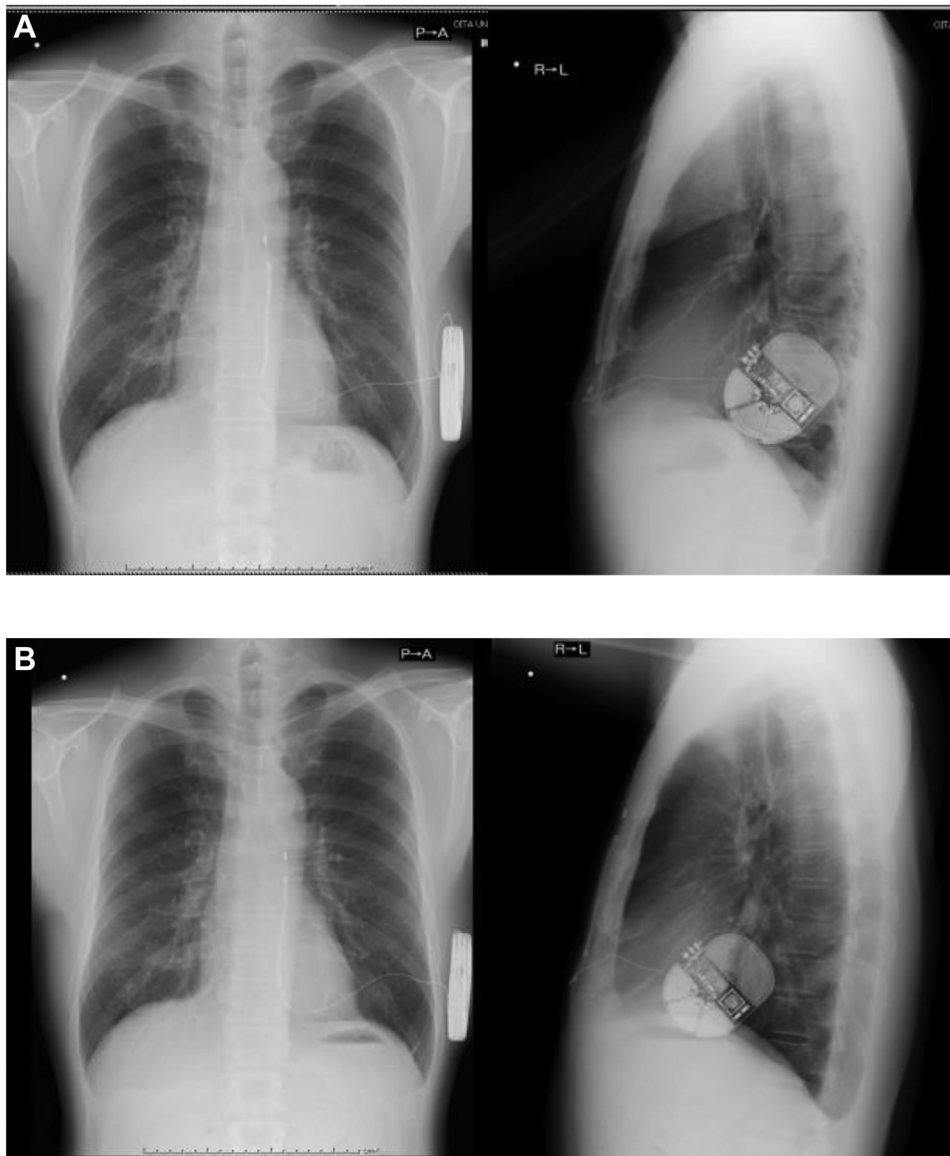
A: Near postoperative chest radiograph. B: Chest radiograph 36 months after implantation.
